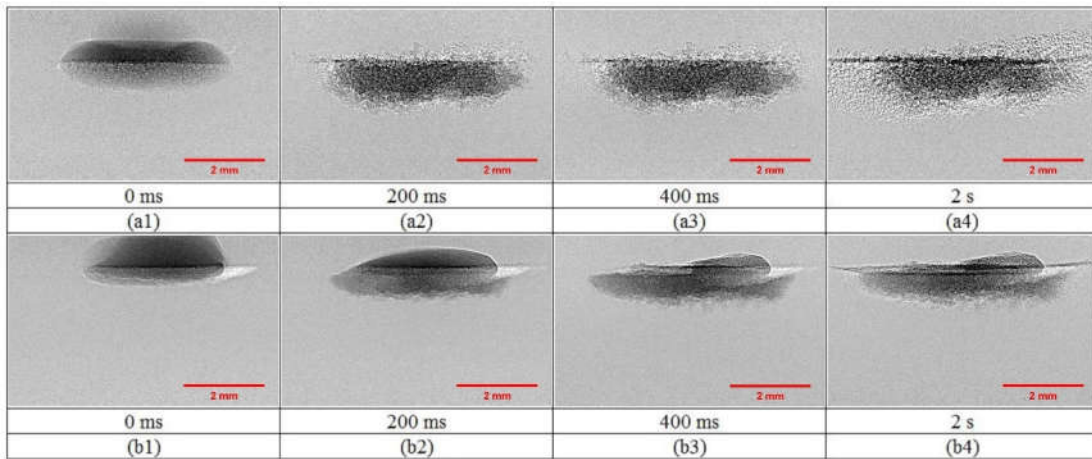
Time sequence X-ray images of the granulation process for MCC (a1-a4) and MCCF (b1-b4) powders with water as a liquid binder with 10 μl volume and 2.5 cm height.
